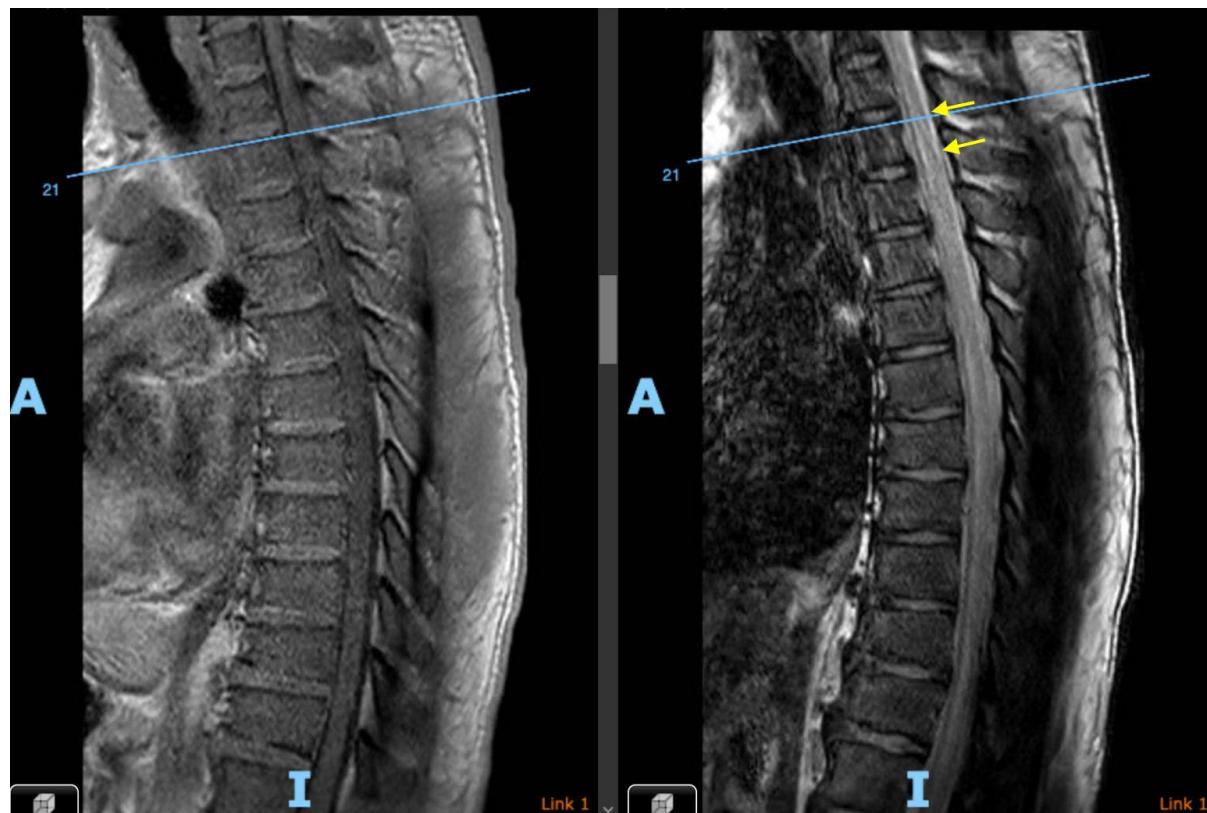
Sagittal view - MRI revealed signs of spinal cord ischemia in the thoracic cord T1-T3 with hyperintense lesions of the posterior horn of the thoracic cord at the level of T1-T3 (yellow arrow)
